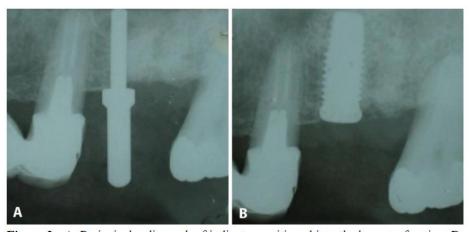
A. Periapical radiograph of indicator positioned into the bone perforation; B. Periapical x-ray of the implant placed.
